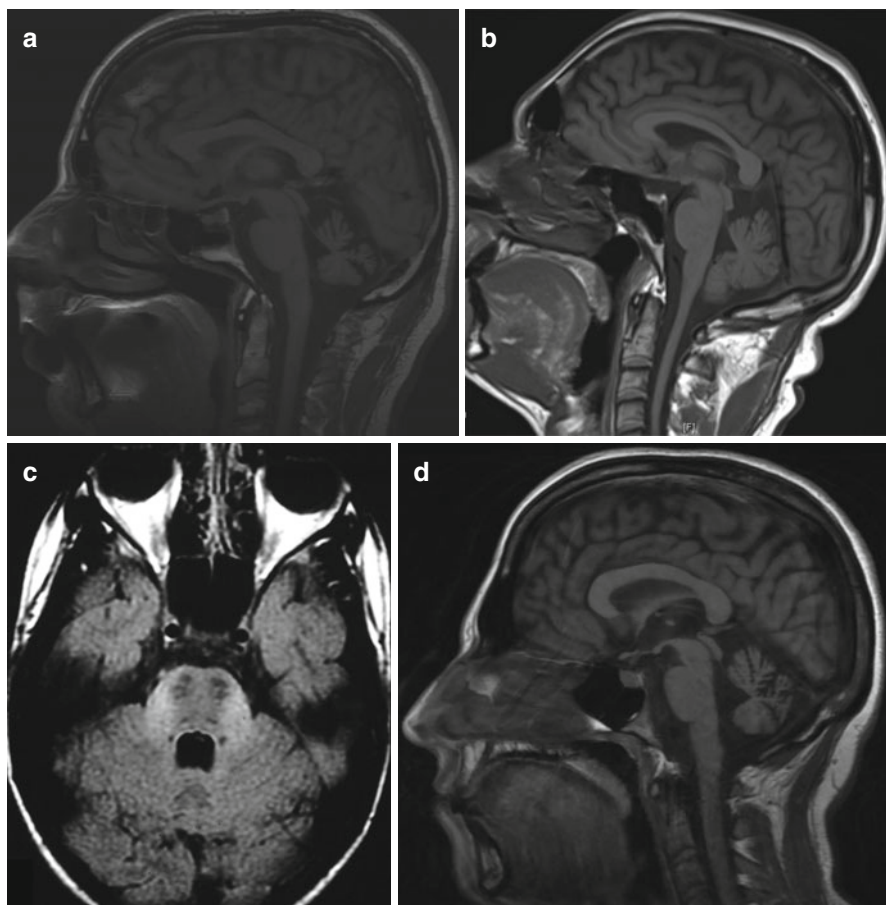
Cerebellar MRI imaging of different ARCA. (a) Ataxia with oculomotor apraxia type 2 (AOA2) with marked cerebellar atrophy; (b) Friedreich ataxia without obvious cerebellar atrophy; (c) autosomal recessive spastic ataxia of Charlevoix–Saguenay (ARSACS) with linear hypointensities in the pons; (d) Niemann–Pick type C disease (NPC): marked cerebellar atrophy
